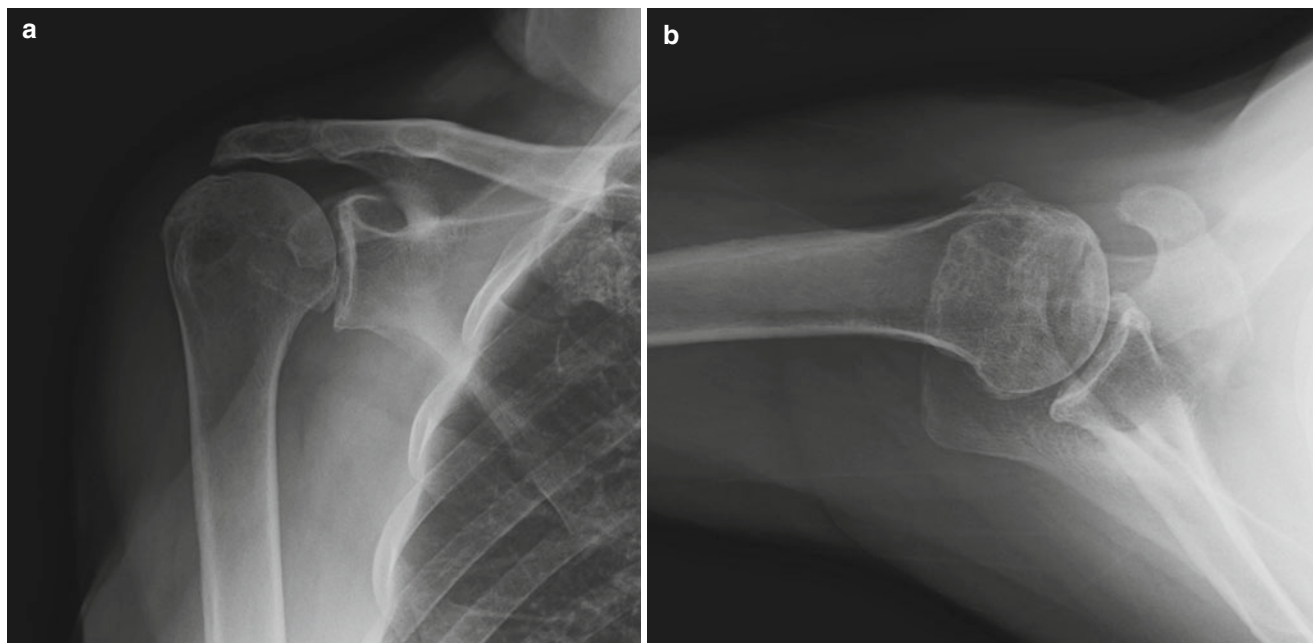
(a, b) AP and axillary lateral radiographs demonstrate stereotypical changes of rotator cuff arthropathy with proximal humeral head migration, femoralization of the humeral head, acetabularization of the acromion, and minimal surgical neck osteophyte formation
